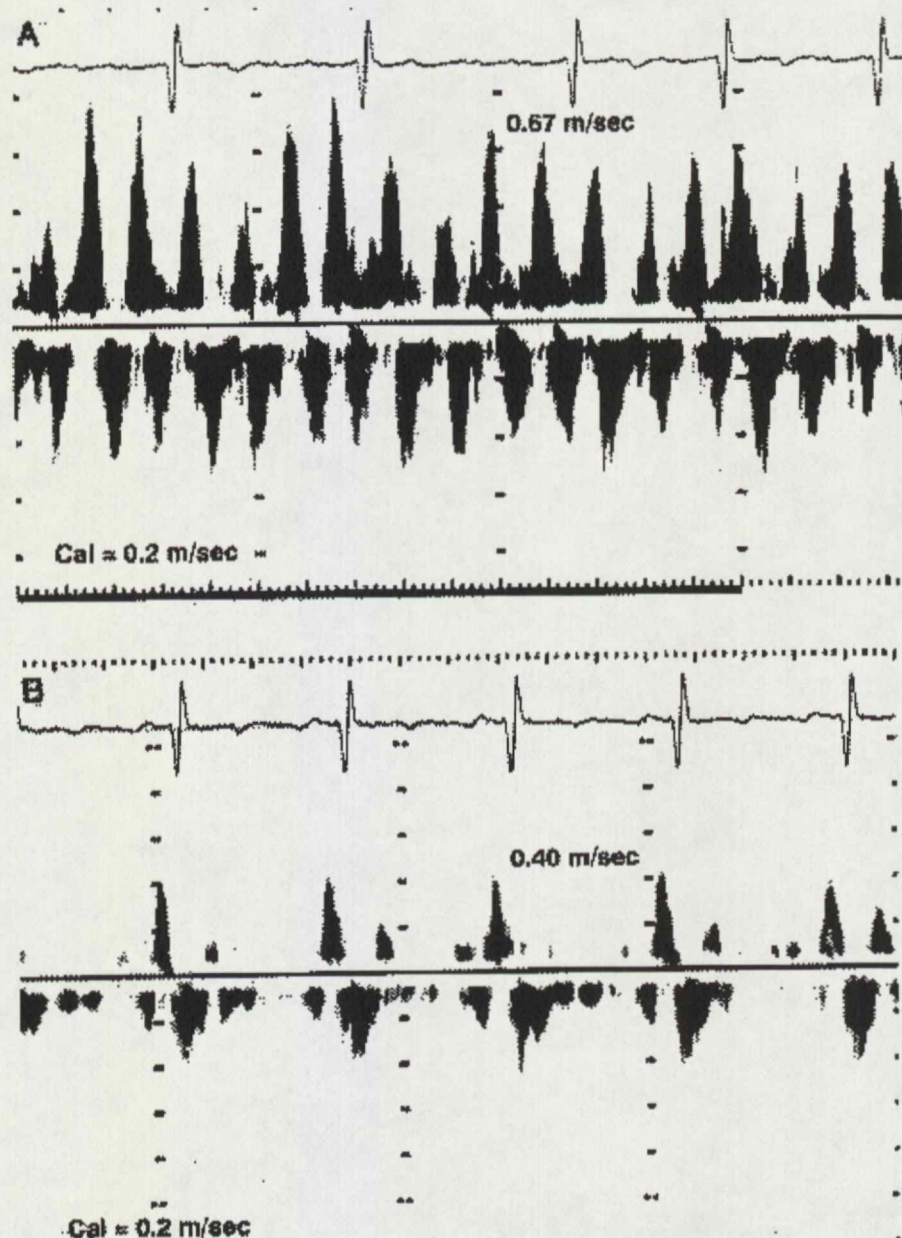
Pulsed Doppler Flow Profiles From Patient 2 in Atrial Flutter (A) and in Sinus Rhythm (B) Immediately After Spontaneous Conversion.
